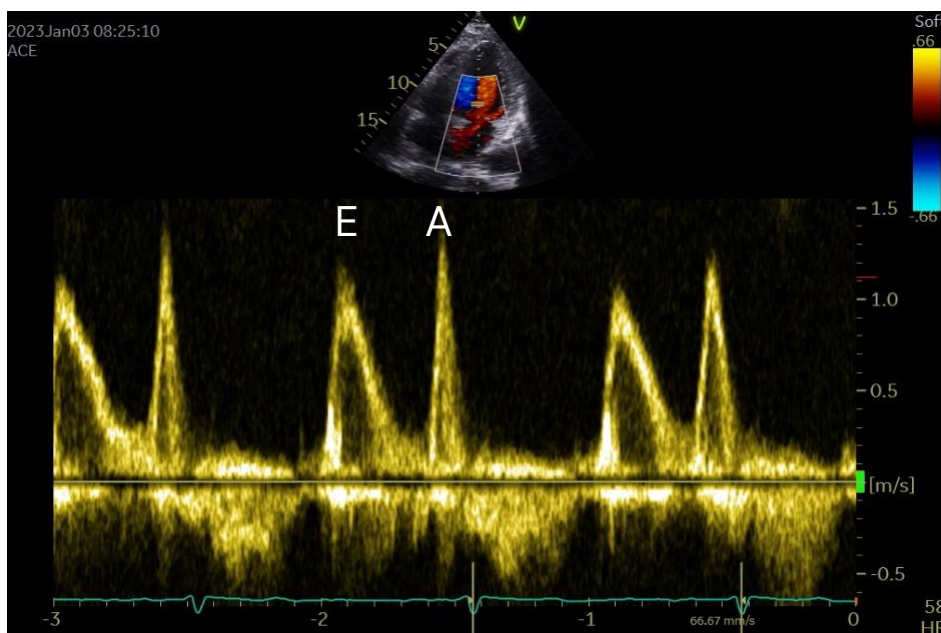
Mitral inflow as visualized by PW-Doppler. X-axis displays time (s), y-axis velocity (m/s). Three cardiac cycles are shown, with the E- and A-waves marked in the middle one.
